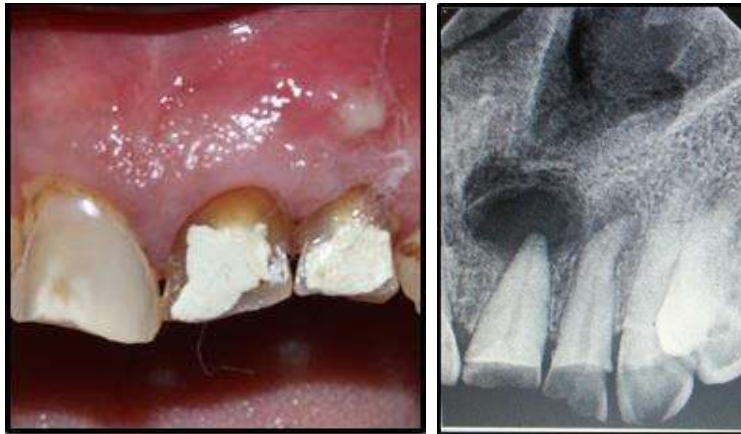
1(a). Presence of Sinus. (b) Radiograph Showing Large Periapical Lesion
